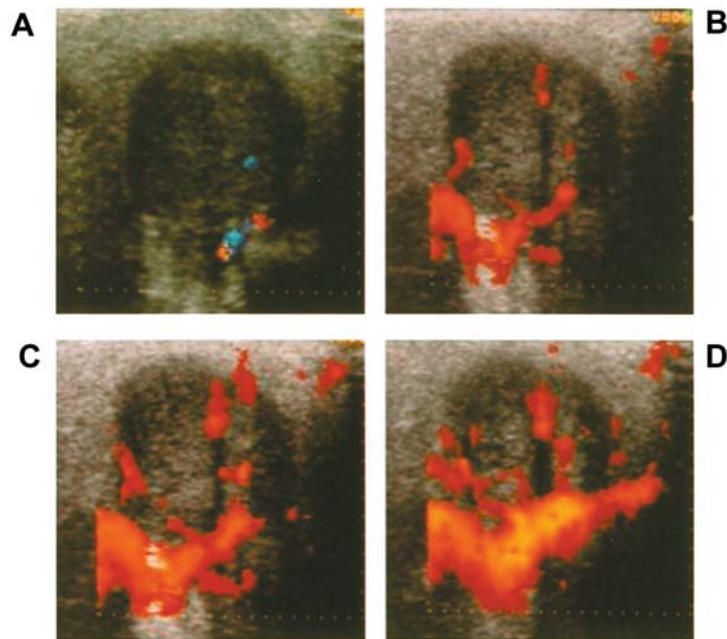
Pleomorphic adenoma. A) Basic color-Doppler: only two small peripheral vascular poles. B-C-D) Echo-color-Doppler 30, 60 and 90 seconds after injection of Levovist: considerable progressive increase in vascular signals, which were for the most part localized peripherally.*
